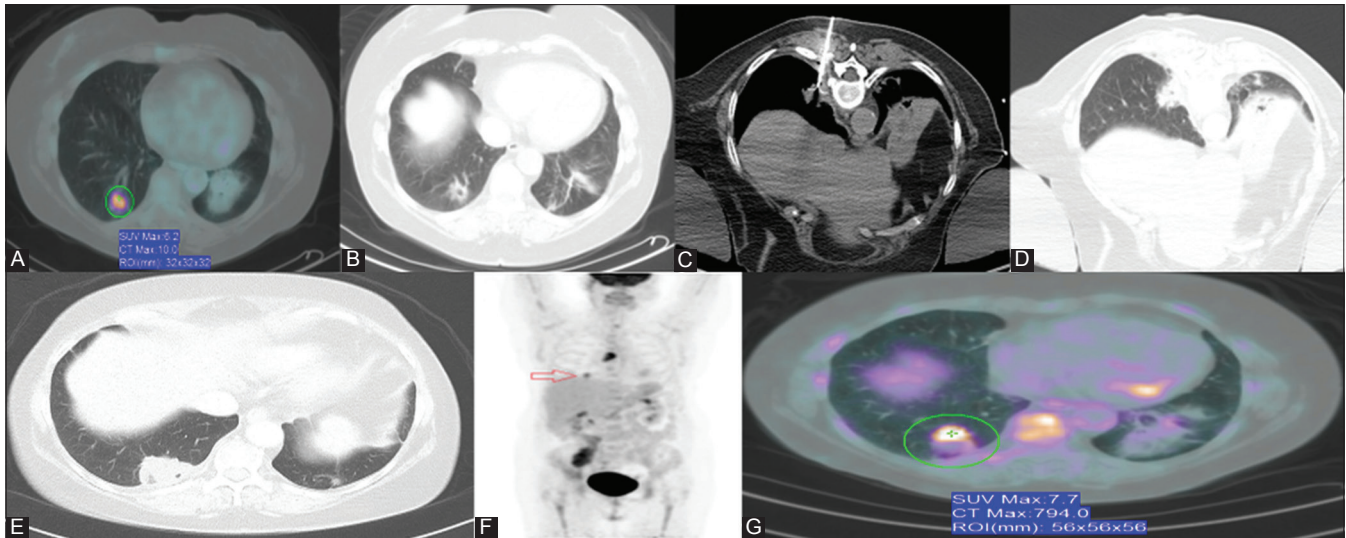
(A-E): A 65-year-old male with NSCLC. Pre-RFA PET-CT (A) and CT (B) Scans show a cavitary lung nodule 1.6 × 1.5 cm in the right lower lobe, SUV 6.2 (C) CT-guided RFA performed (D) Large area of GGO is seen around the nodule (E) CT at 6 weeks shows a large solid nodular area now measuring 2.9 × 2.6 cm. PET-CT MIP images (F) and axial images (G) at 3 months show FDG uptake in the nodule, SUV 7.7 (red arrow in F) compared to prior SUV 6.2 and measuring 2.9 × 2.6 cm, with photopenia/necrosis in the posterior half of the lesion
